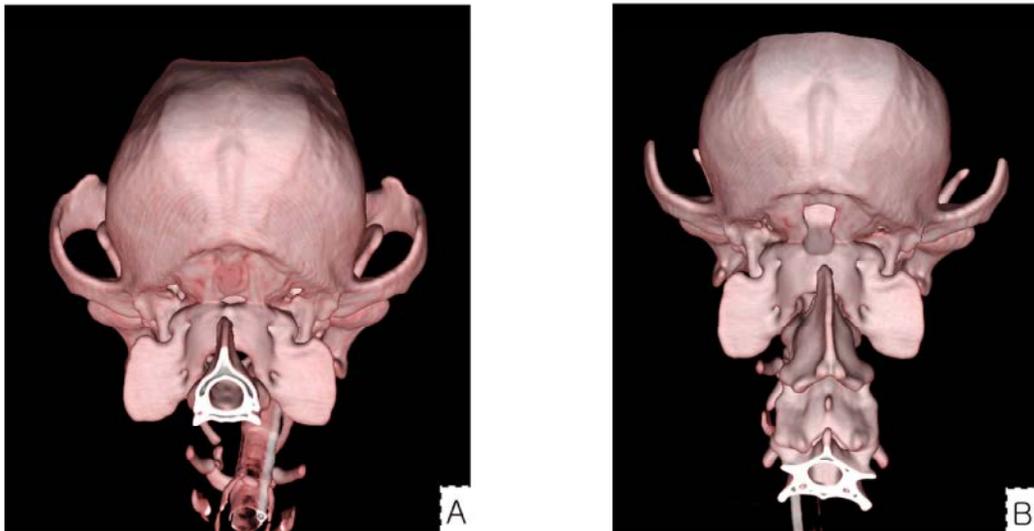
3-D CT scan of pre-operation (A) and post-operation (B).
